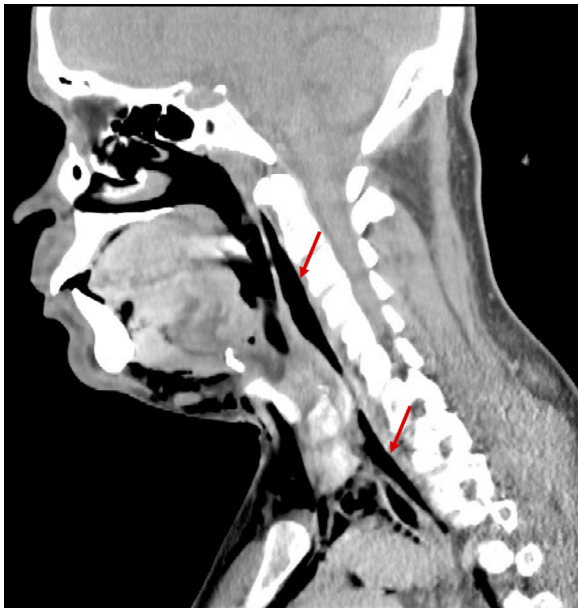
Sagittal view of a computed tomography (CT) neck scan without contrast. There is air emphysema tracking from the posterior oropharynx to the mediastinum (red arrows) through the retropharyngeal/danger space. There is also prominent submandibular and superficial air emphysema.
